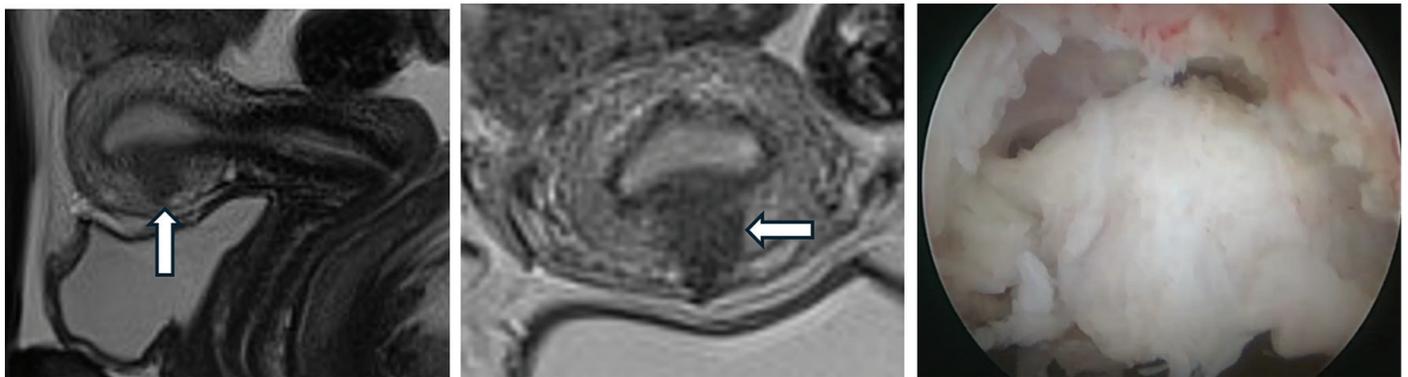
JZ-MRI ReproClass C small focal pathology corresponding with hysteroscopic view during excision. JZ-MRI: junctional zone-magnetic resonance imaging.
